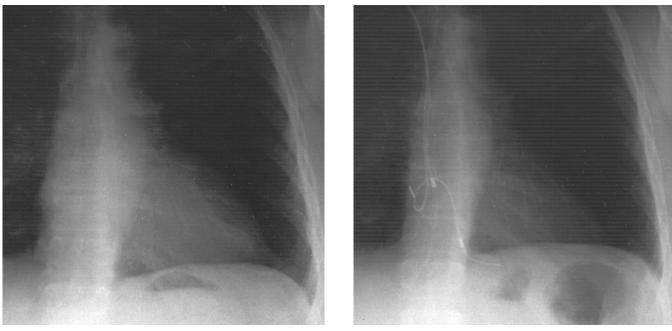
Thoracic x-ray pre-implantation (left picture), 3 month after implantation (right picture).
